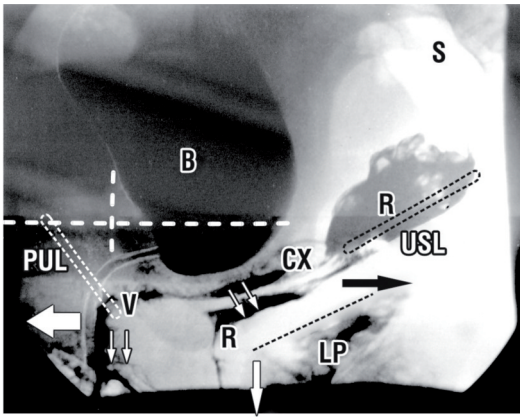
Straining x-ray. Any stimulus (straining, coughing, intercourse) which stimulates fast-twitch muscle contractions stretch the vagina and rectum backwards and downwards by 3 directional muscle forces acting against PUL and USL. This action narrows the vagina and grasps the penis tightly.
